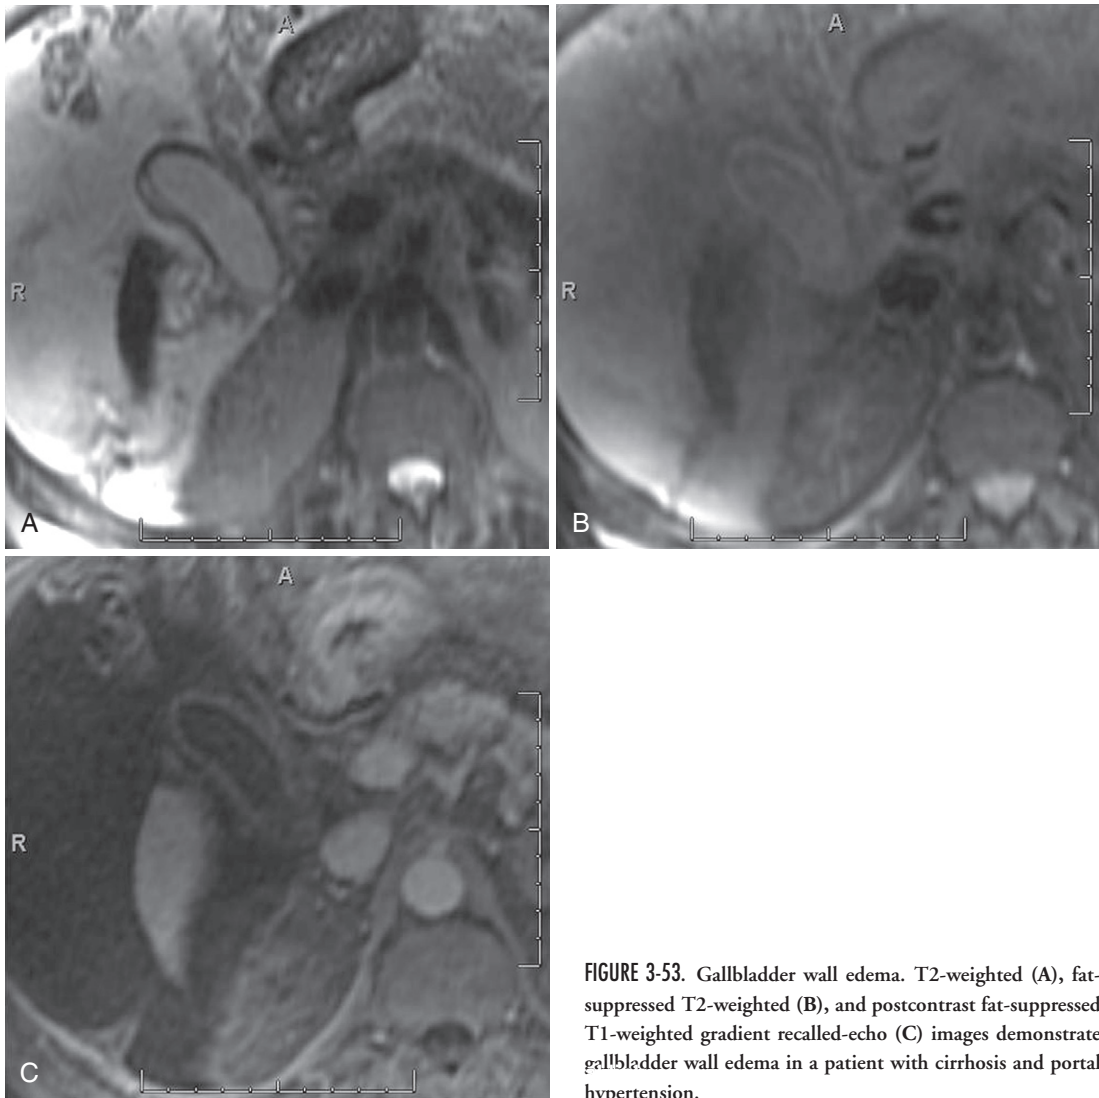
Gallbladder wall edema. T2-weighted (A), fat-suppressed T2-weighted (B), and postcontrast fat-suppressed T1-weighted gradient recalled-echo (C) images demonstrate gallbladder wall edema in a patient with cirrhosis and portal hypertension.
